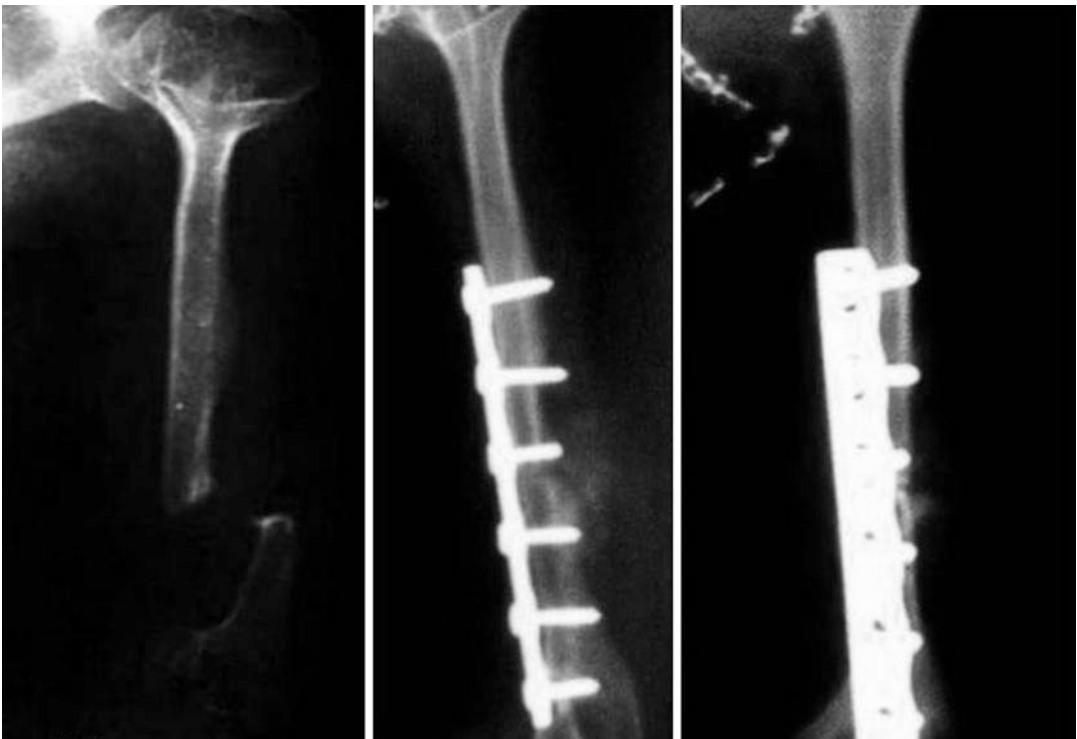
Left: Atrophic nonunion of fracture of humerus. Middle: Follow-up anteroposterior and (right) lateral radiographs showing union
